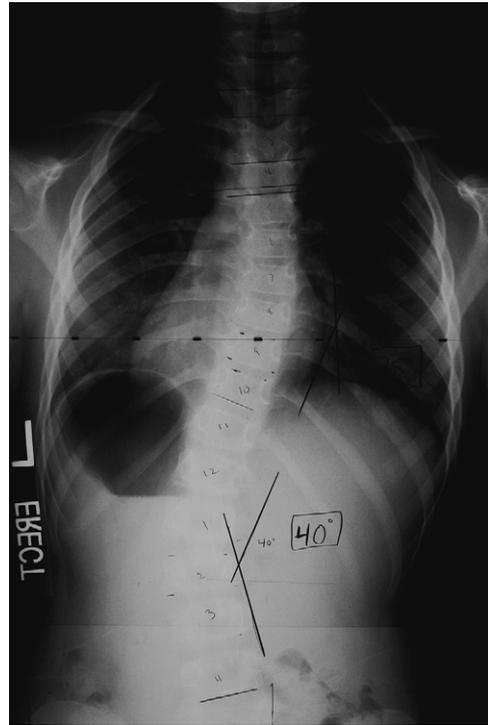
Posteroanterior radiograph of a 7-year-old girl with idiopathic scoliosis having a 25° thoracic and 40° lumbar curve.
